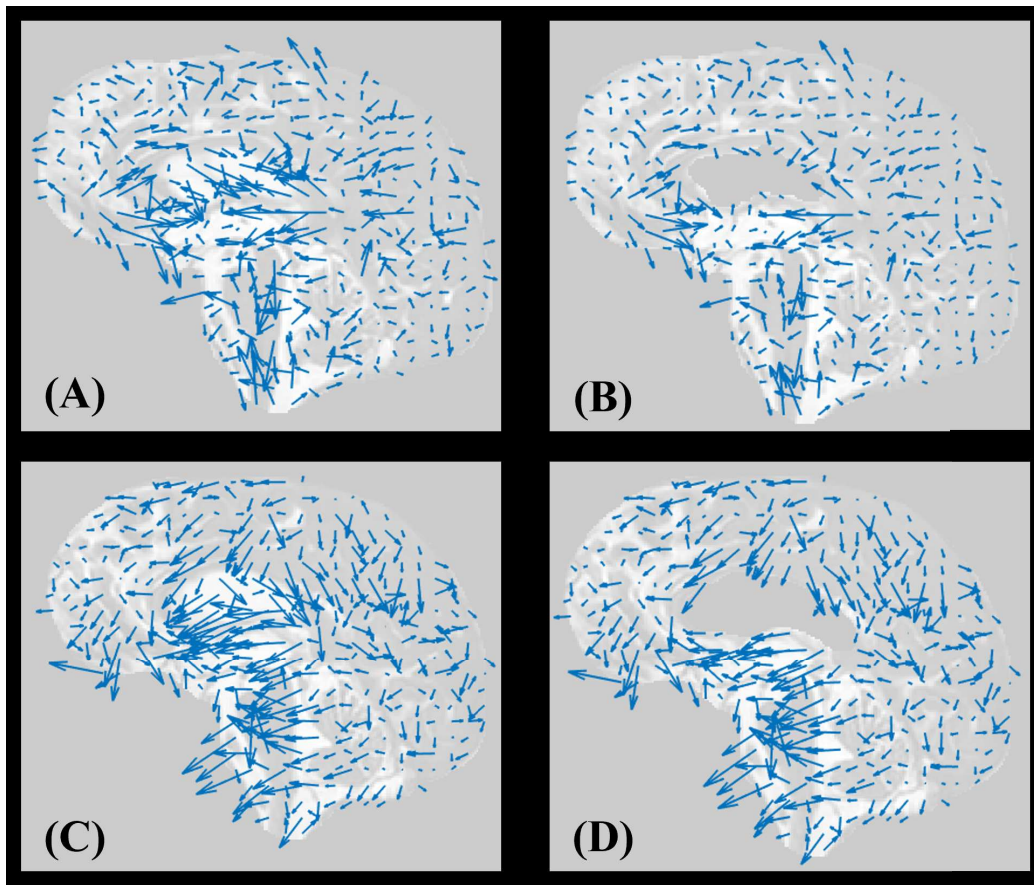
1st modeshape of 3D amplified cine MRI for an NPH patient before and after shunt surgery. (A) 1st modeshape of 3D amplified cine MRI pre-shunt, with CC included. (B) 1st modeshape of 3D amplified cine MRI pre-shunt, with CC excluded. (C) 1st modeshape of 3D amplified cine MRI post-shunt, with CC included. (D) 1st modeshape of 3D amplified cine MRI post-shunt, with CC excluded.
